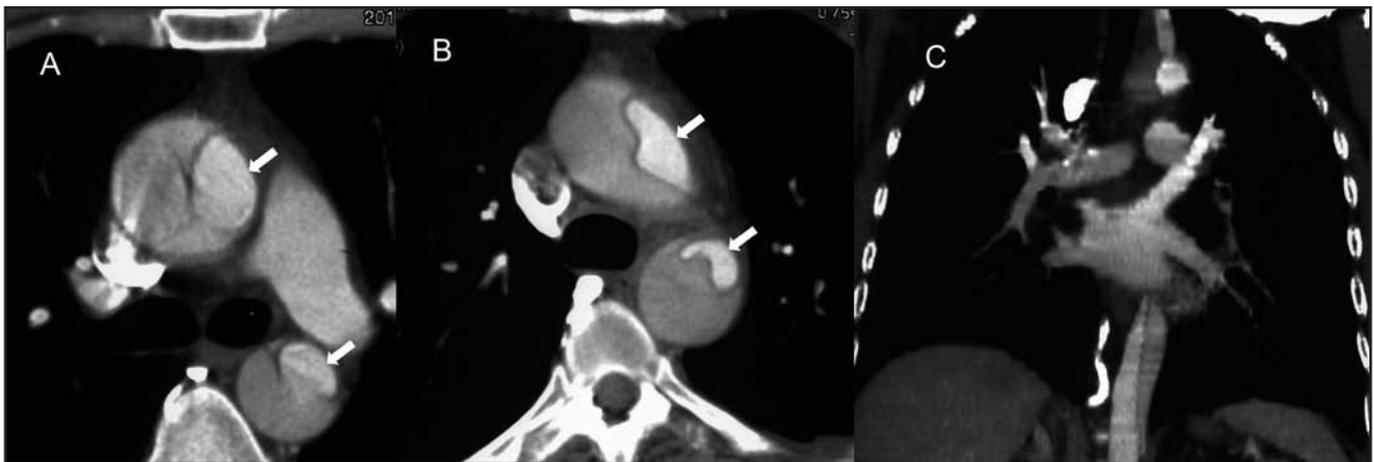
Thoracic Angio-CT.
